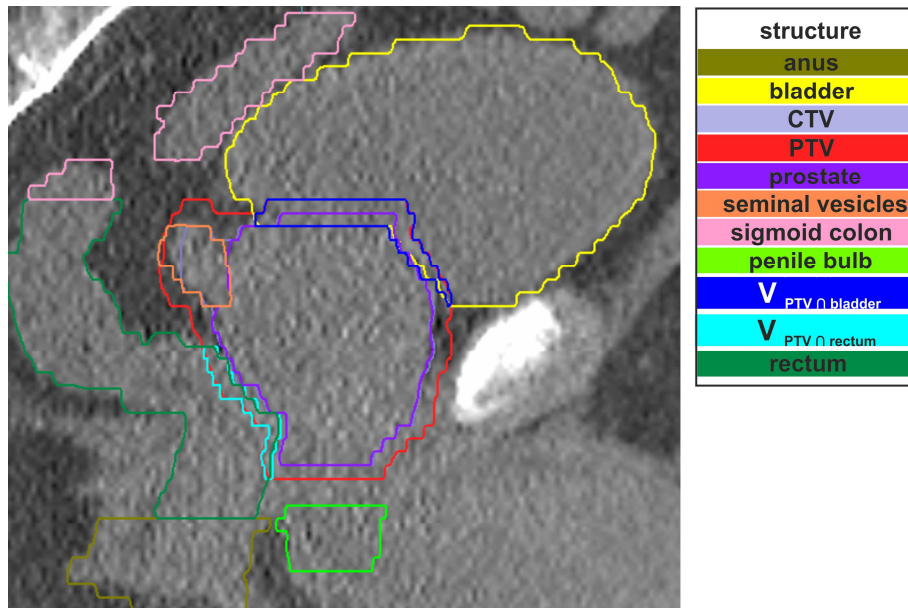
Overlap volume between the PTV and the bladder (dark blue) and between the PTV and the rectum (light blue) for a sagittal slice of the planning CT of an exemplary patient.
